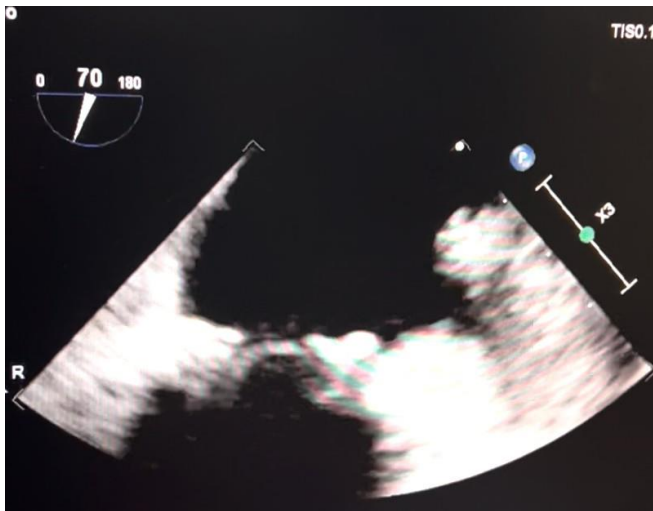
The echocardiography showing the disappearance of vegetation after Surgery
